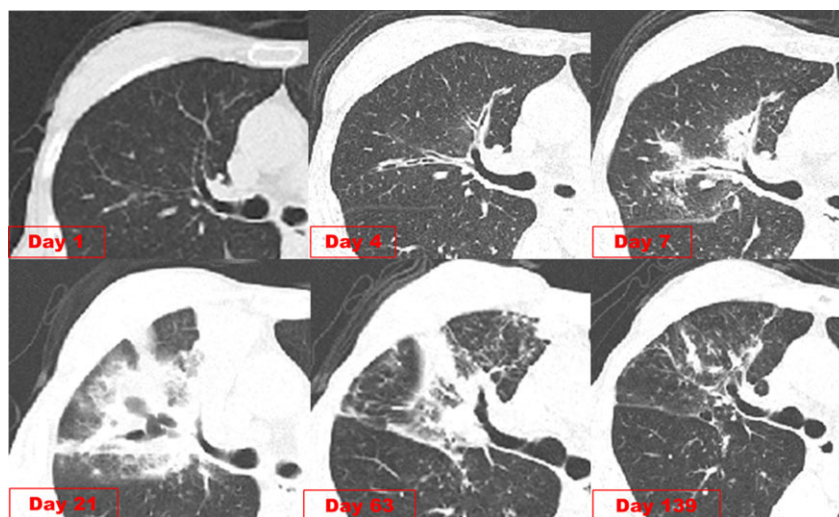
Thoracic computed tomography (CT) of the right upper lobe. The initial CT showed no abnormality. Four days after admission, CT showed increased thickness of the bronchial wall. In a short period, the bronchiole was obstructed and enlarged. Extended parenchymatous opacity was observed along the obstructed bronchi 7 days after admission. Twenty-one days after admission, progression of consolidation including cystic bronchiectatic lesions. Sixty-three days after admission, CT showed remarkable improvement of the infiltrative shadows. One hundred thirty-three days after admission, most infiltrative shadows had disappeared.
